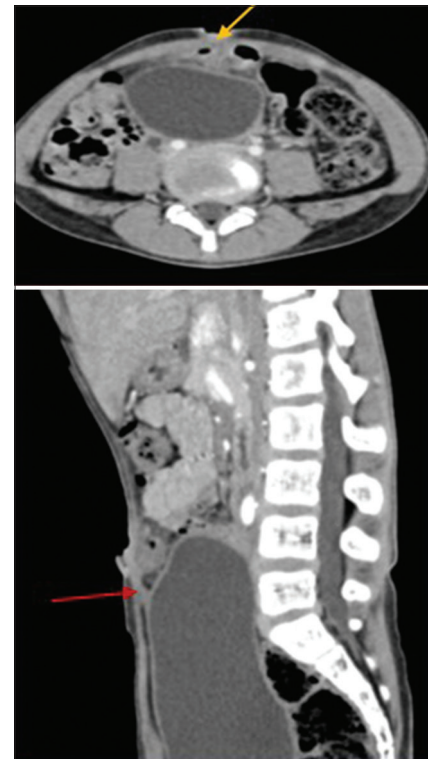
On contrast-enhanced computed tomography axial view, collection (yellow arrow) is noted in periumbilical region adherent to ileal loops. On sagittal view, collection is seen and also a fibrous cord like structure (red arrow) is seen connected to dome of urinary bladder.
